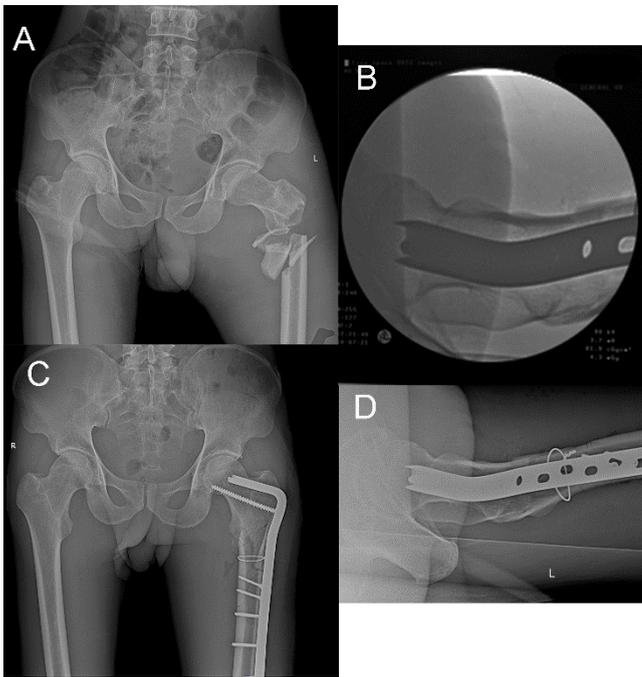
A: Preoperative anteroposterior view of the left comminuted subtrochanteric fracture. B: Intraoperative true lateral view of the hip at the lateral decubitus position. C, D: Early post-operative radiographs
